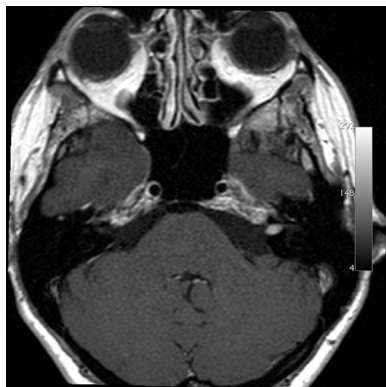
Contrast-enhanced magnetic resonance imaging showing a right pure intracanalicular vestibular schwannoma.
